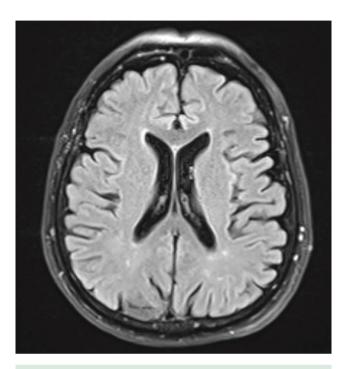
Magnetic resonance imaging of the brain, second day of illness. Stroke not detected.
